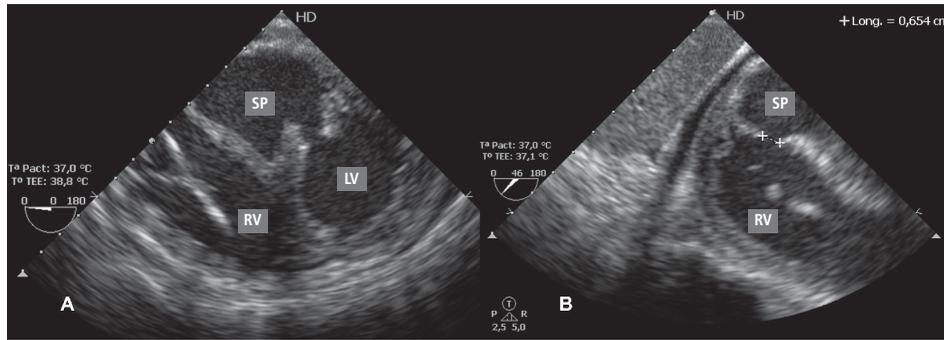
Intraoperative transesophageal echocardiography. A. Communication between the left ventricle (LV) and the septal pseudoaneurysm (SP). B. Communication between the septal pseudoaneurysm (SP) and the right ventricle (RV).
